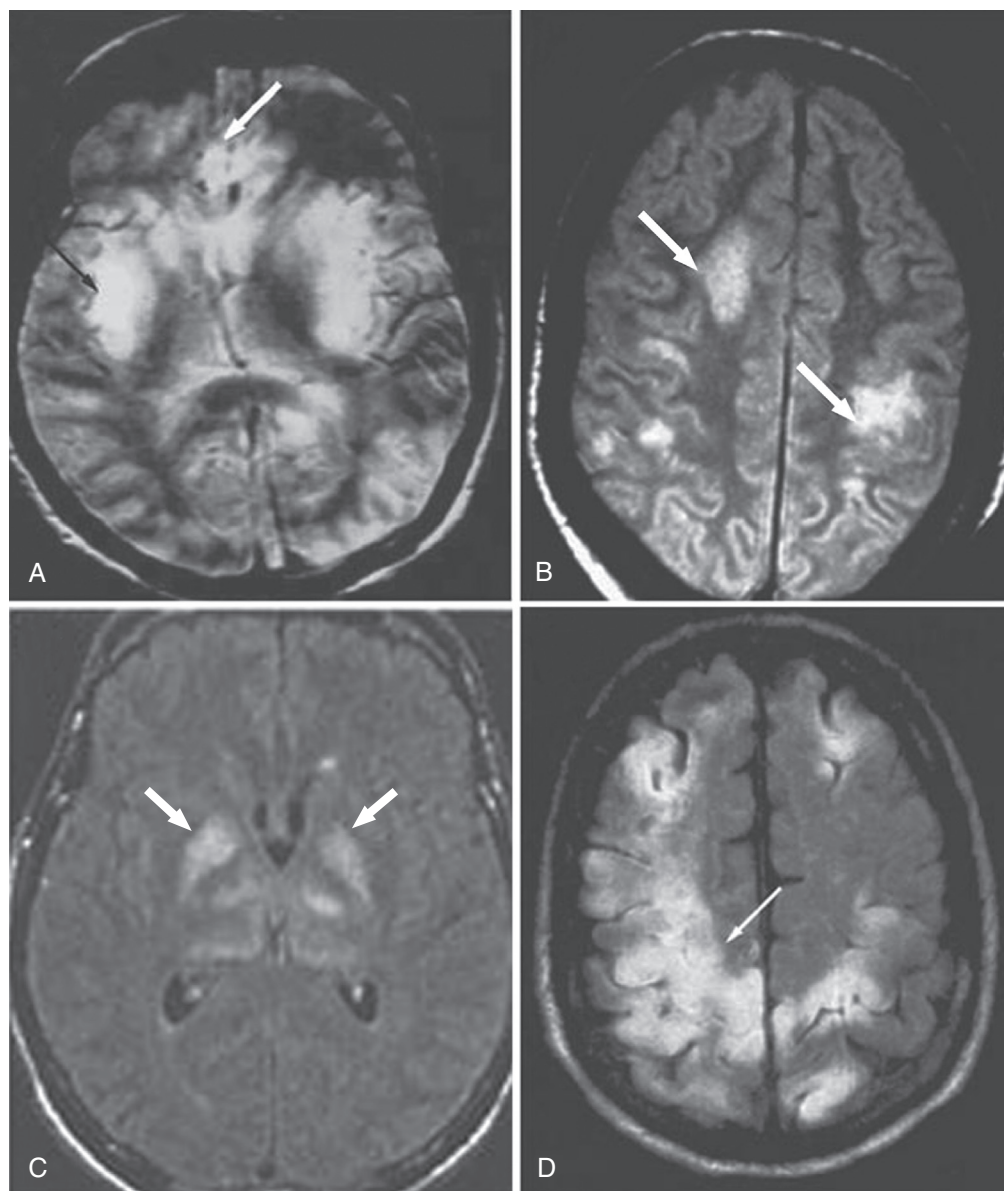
Typical magnetic resonance imaging (MRI) changes associated with viral encephalitis. (A) Herpes simplex virus type 1 encephalitis with increased T2-weighted signal in bilateral temporal lobes. Increased signal does not extend beyond the insular cortex (*black arrow*) but does involve the cingulate gyrus (*white arrow*). (B), Varicella-zoster virus vasculopathy on proton-density MRI scan with multiple areas of infarction in both hemispheres (*arrows*). (C) West Nile virus encephalitis with increased signal on FLAIR MRI image of the basal ganglia (*arrows*). (D) Enterovirus encephalitis with increased signal intensity on FLAIR MRI image in both hemispheres, greater on the right, in the posterior cerebral hemisphere (*arrow*). (Modified from Gilden DH, Mahalingam R, Cohrs RJ, Tyler KL. *Herpesvirus infections of the nervous system*. Nat Clin Pract Neurol. 2007;3:83; and DeBiasi RL, Tyler KL. *West Nile virus meningoencephalitis*. Nat Clin Pract Neurol. 2006;2:264.)
